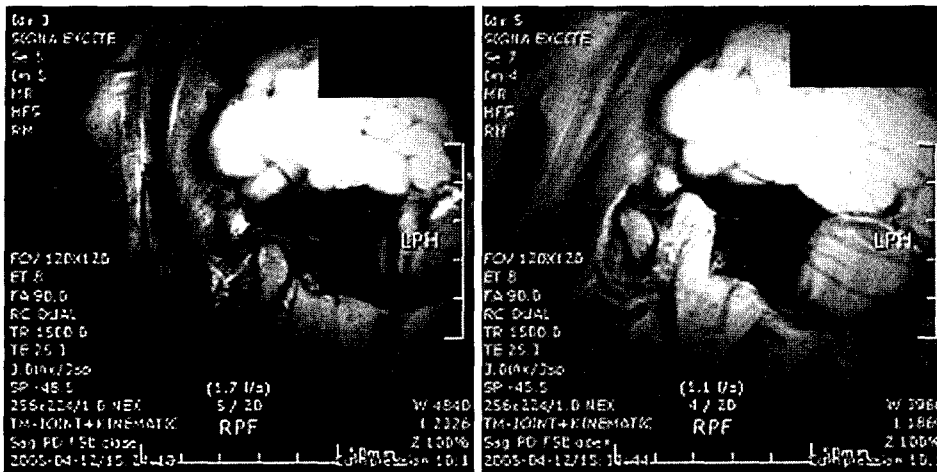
The static MRI of TMJ ID with reduction.
